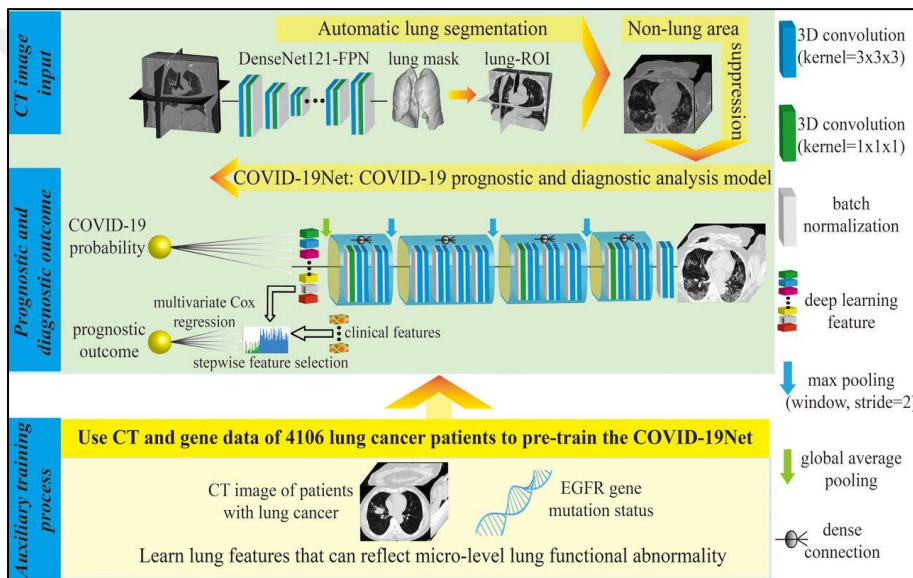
Proposed CNN model to classify lung CT images (Wang et al., 2020).
